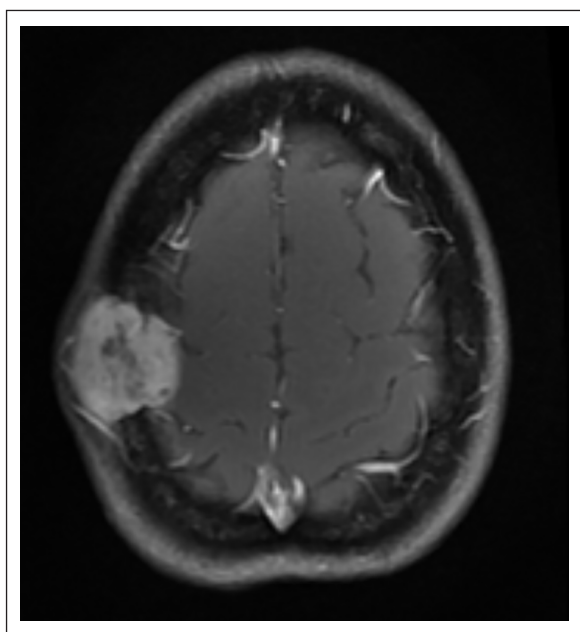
Imaging: MRI axial T1 pre-op. Axial T1-weighted post-contrast image, from 29/4/2015, shows an avidly enhancing 3.6-cm right parietal calvarial mass with minimal extension into the adjacent extra-axial space. There are no additional enhancing lesions.
